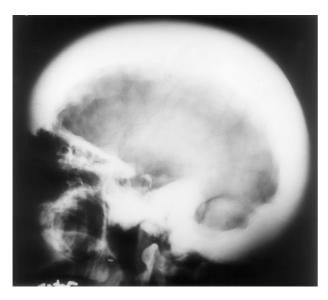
Lateral skull radiograph of an adult with sclerosteosis. Gross calvarial thickening is evident.
